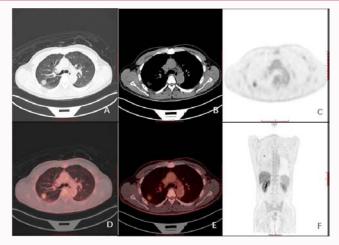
A 50-year-old male suffered from rheumatoid arthritis for more than 20 years. CT images in the lung window (A) can see a nodular shadow, the boundary is unclear, and burrs can be seen at the edge, increased metabolic activity confirming the presence of ongoing inflammation (D). Soft tissue window (B) showed low density in nodules, metabolic activity is also uptake (E). Axial position (C) and Coronal position (E) in PET.
